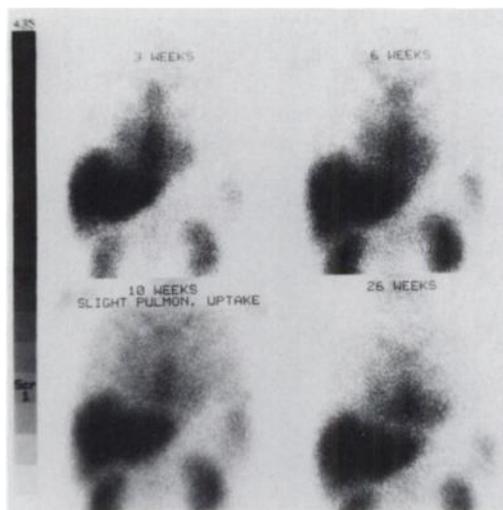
Antimyosin scintigrams 3, 6, 10 and 26 wk after heart transplantation in Patient 2 demonstrate slight pulmonary uptake at 10 wk, where evidence of *Pneumocystis pneumonia* was present.
